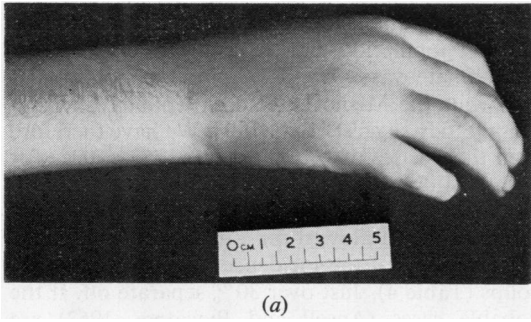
(a, b) Swelling over wrist and carpus was present for 11 months. Initially the x-ray was normal, but by now, (3b), it had characteristic leukaemic changes.
